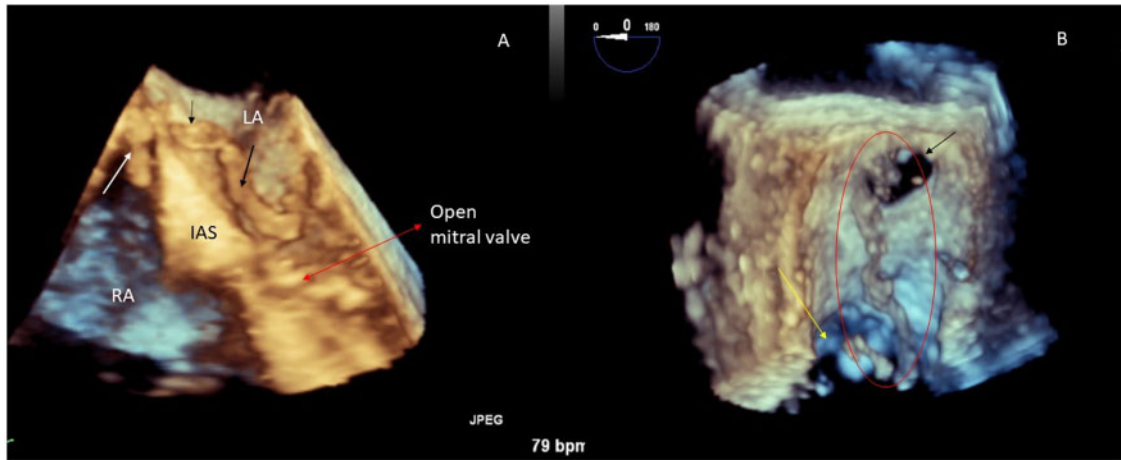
(A) Still image from transoesophageal echocardiography at the mid-oesophagus, 0°, with focus on inter-atrial septum, showing the right atrium, left atrium, left ventricle, and mitral valve (red arrow). Also seen is the thrombus in transit going from the right atrium to left atrium (blue arrows) through a patent foramen ovale and prolapsing into the left ventricle through the mitral valve in diastole. (B) Focused view of left atrium and left ventricle in the beginning of the diastole shows the long serpentine thrombus in left atrium (white arrow).
